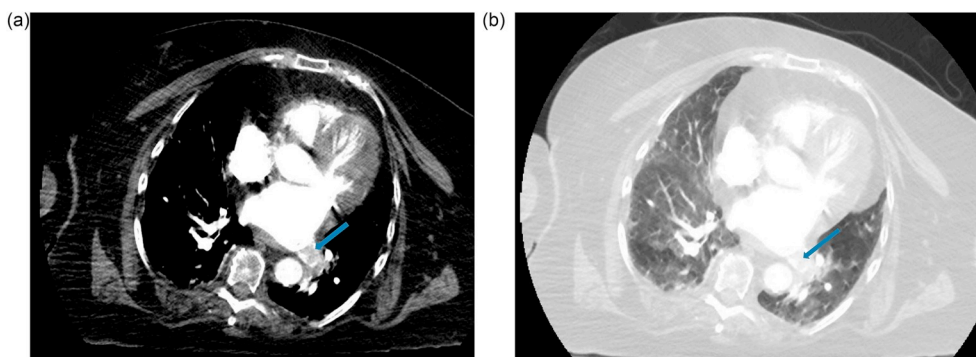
a & 1b: Chest CT demonstrating a filling defect within the confluence of left lower pulmonary vein at the junction with the left atrium seen on both chest/abdomen view (Fig. 1a) and lung view (Fig. 1b).
